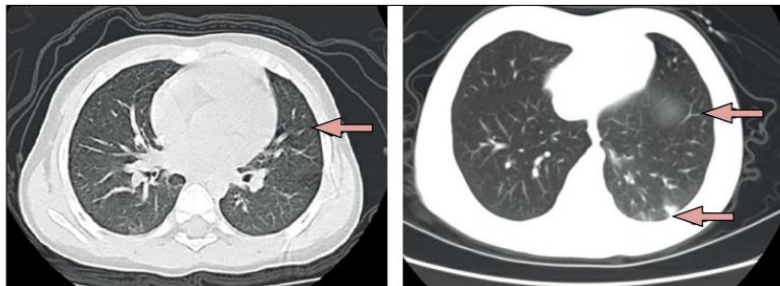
Chest CT scans from two paediatric patients with coronavirus disease 2019 (Left) CT of 10-year-old boy showing multiple opacities in lower lobes of both lungs (arrow). (Right) CT of 1.5-year-old girl showing multiple ground-glass opacities with a big patchy opacity in the right lung (arrows).
